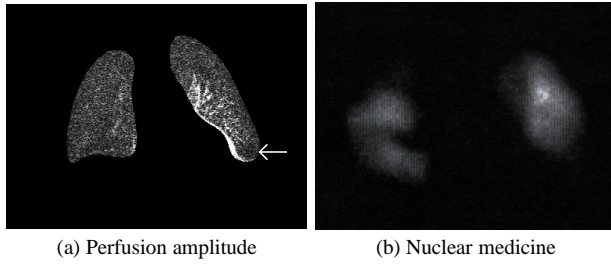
Case 2: (a) Overall reduced perfusion (RP) of the right lung. Overactive perfusion (OP) is seen centrally in the left lung, while reduced perfusion (RP) is shown in the left apex and a small area (indicated with an arrow) in the upper left lung field. Pulmonary embolism in the right lung and in the superior segment of the left lower lobe shown by CT and NM (b) studies. Generally, the NM image shows the perfusion activity in the anterior parts of the lungs, while our perfusion amplitude image reveals perfusion through the lungs. Therefore, the reduced perfusion of the lower part of the right lung shown by our method (a) may be explained by the thrombotic mass in the hilar region of the right lung as reported by CT.
